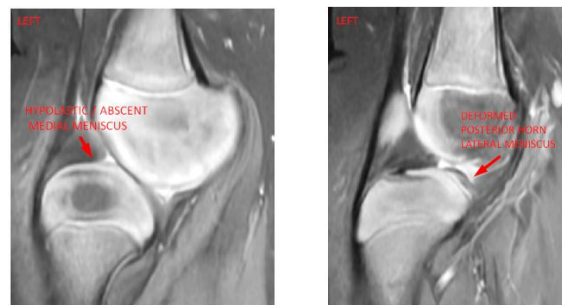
Left Knee MRI in Sagittal Pdfs Shows Hypoplastic / Absent Medial Meniscus and Deformed Posterior Horn of Medial Meniscus¹⁰
